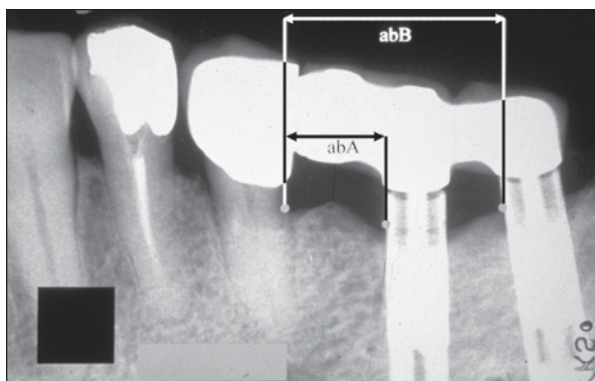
Radiograph of a tooth/implant-supported FPD for measuring tooth-implant 1 (abA) and tooth-implant 2 (abB) distances. The black box in the lower left corner served as a reference square for calculating the amount of peri-implant bone loss.
